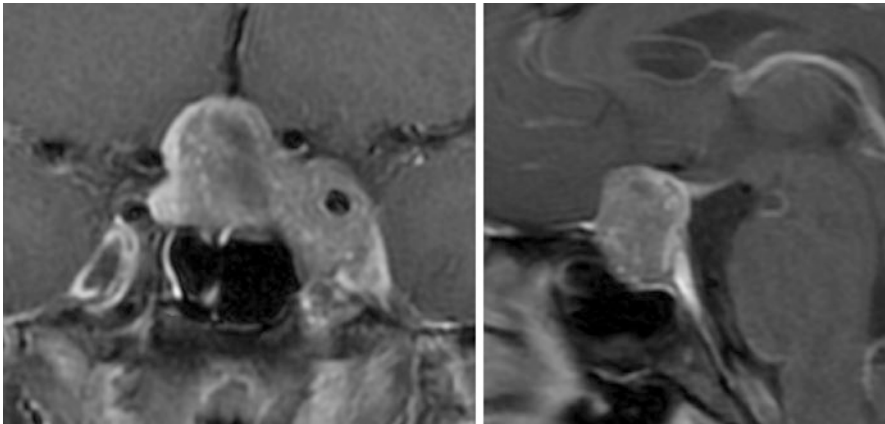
MRI appearance of a pituitary macroadenoma involving the cavernous sinus. Coronal (left) and sagittal (right) T1-weighted post-contrast images show a large pituitary mass with heterogeneous enhancement. There is both suprasellar extension and invasion into the left cavernous sinus that encases the left cavernous internal carotid artery, but does not narrow it
